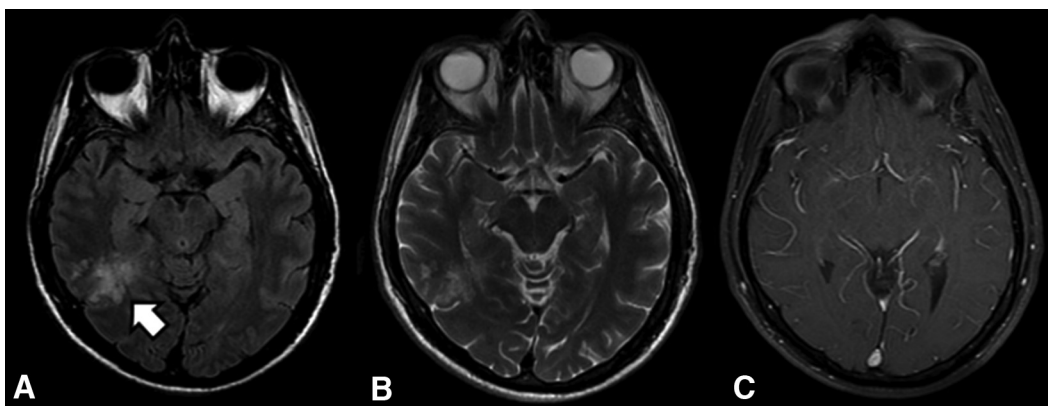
MVNT. Axial FLAIR (A), T2WI (B), and postcontrast T1WI (C) show confluent small nodular lesions located predominantly in the subcortical white matter of the right temporal region. There is hyperintensity on FLAIR imaging (arrow in A) and T2WI (B) with no significant enhancement (C) or mass effect. The subcortical white matter adjacent to the small nodules is also slightly hyperintense on FLAIR and T2WI.
